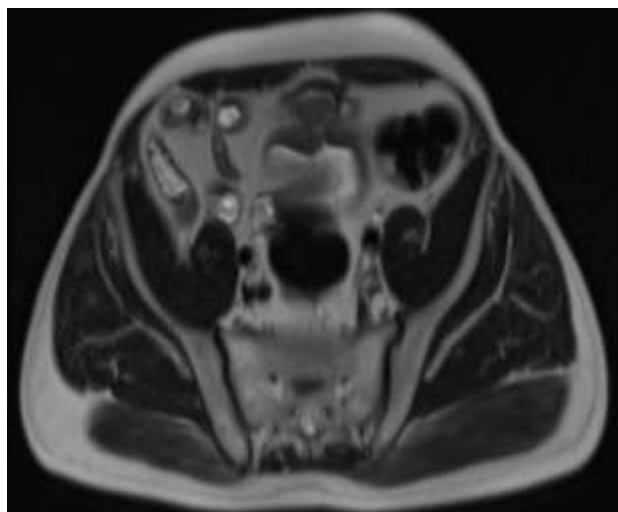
Axial T2-weighted MRI image showing a hyperintense tubular midline structure in the preperitoneal space, consistent with fluid/purulent content within the urachal sinus
